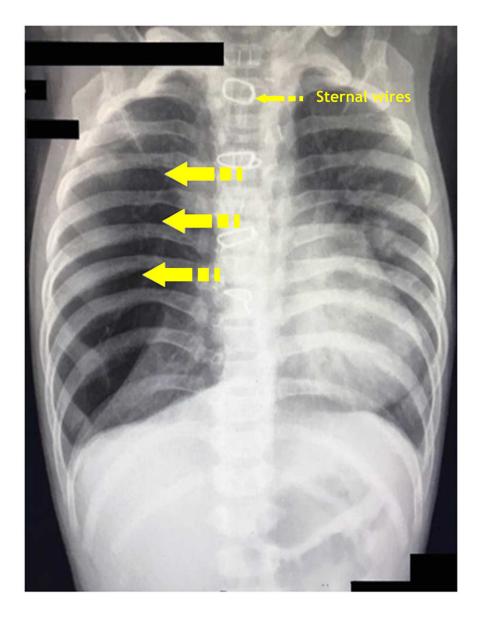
X-ray chest Postero-anterior (PA) view showing clear hyperluceny of the right middle lobe with crowding of right upper and lower lobe with mediastinal shift. Sternal wires from the previous heart surgery can be made out.
